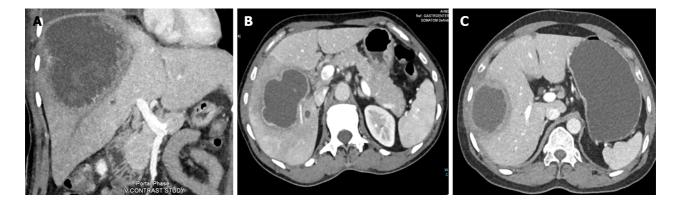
Computed tomographic classification of amebic liver abscess. A: Type I amebic liver abscess (ALA) shows incomplete wall and ragged edges with irregular enhancement; B: Type II ALA showing a complete rim enhancement with peripheral hypodense halo; C: Type III ALA showing a chronic non-enhancing wall.
